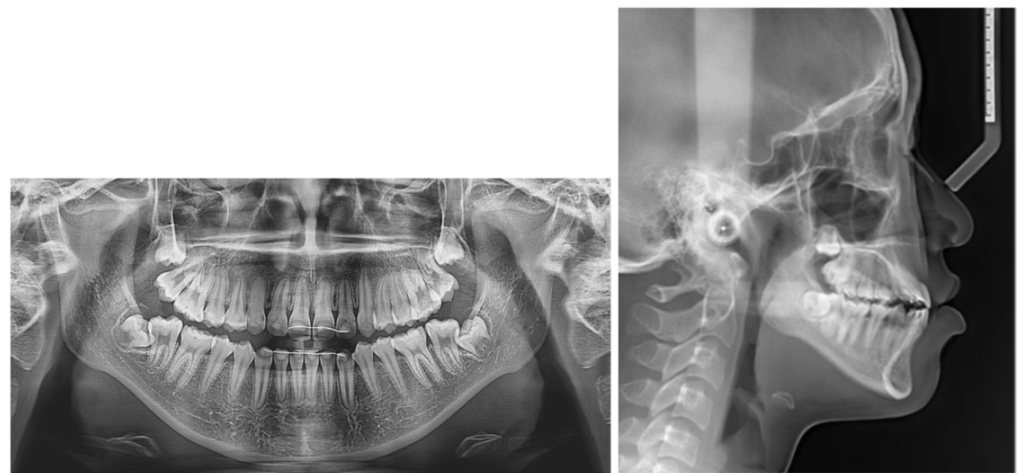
First-phase post-treatment panoramic radiograph and lateral cephalogram.
